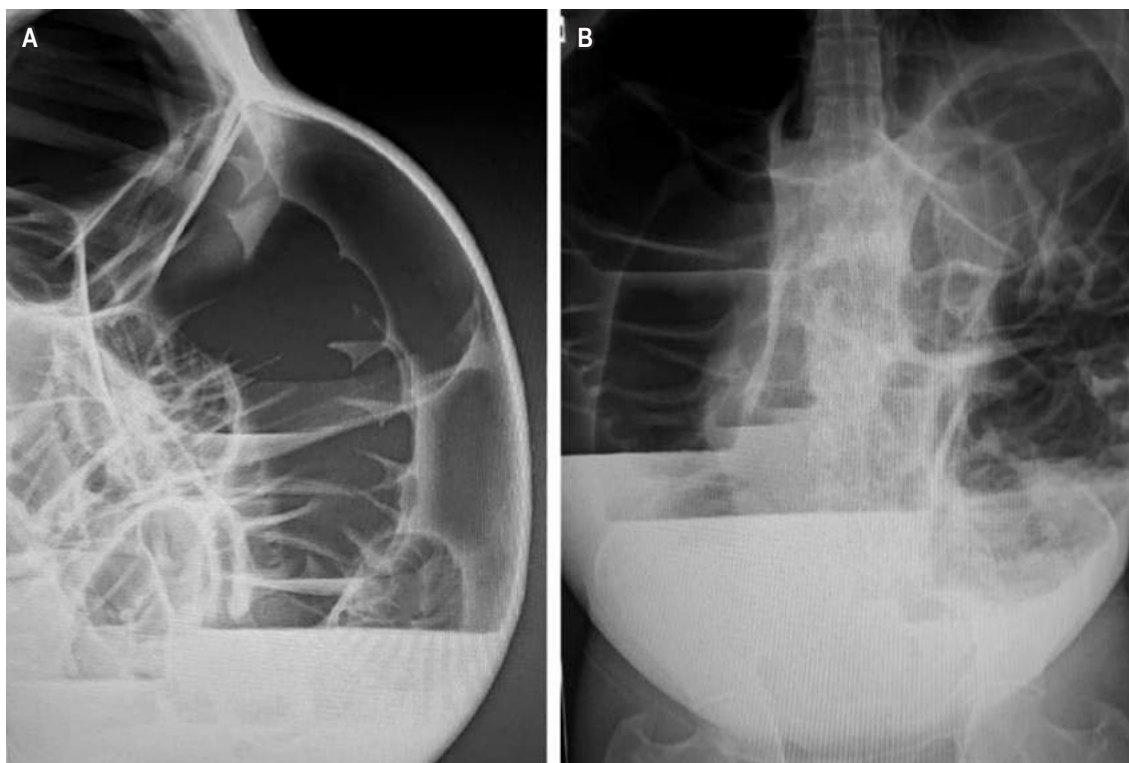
Abdominal X-rays in standing position. A. Lateral view. B. Anteroposterior view.
